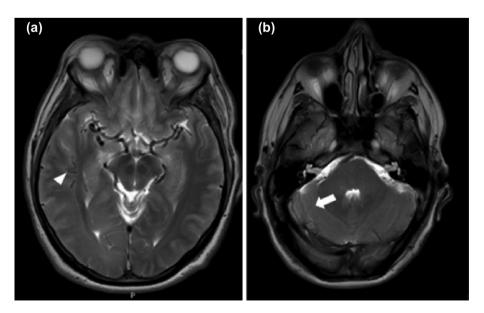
Panel A and B. Axial view of a T2 cerebral MRI showing supra (arrowhead) and infratentorial (arrow) engorged veins, attributable to venous reflux and arterialization secondary to a DAVF.
